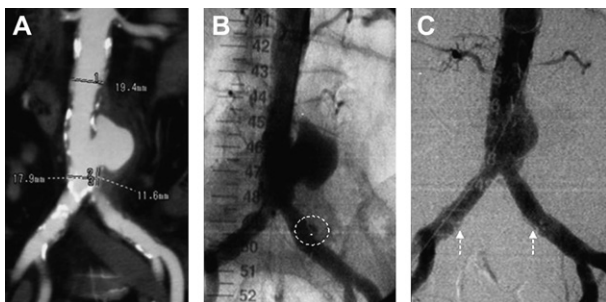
Preoperative CT-angiography of an infrarenal PAU with a 55 mm aortic expansion (A). Intraoperative angiogram (B) confirmed the presence of the PAU just above the aortoiliac bifurcation and the ulceration (ring) of a plaque of the left common iliac artery; both the lesions were excluded with two abdominal “cuffs” and a “kissing”-stent grafts (arrows) reconstruction of the aorto-iliac bifurcation (C).
